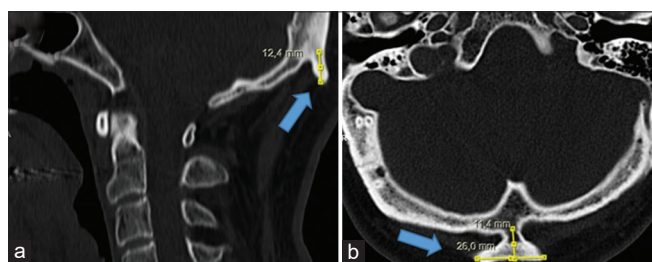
Computed tomography section of the cranium. The tubercle structure in the occipital protrusion is shown with blue arrows. (a) sagittal section view of the external occipital protuberance (EOP) protrusion measured 12.4 mm in length, (b) axial section view of the EOP protrusion measured 26 mm in width and 11.4 mm in thickness between the two most distal points
